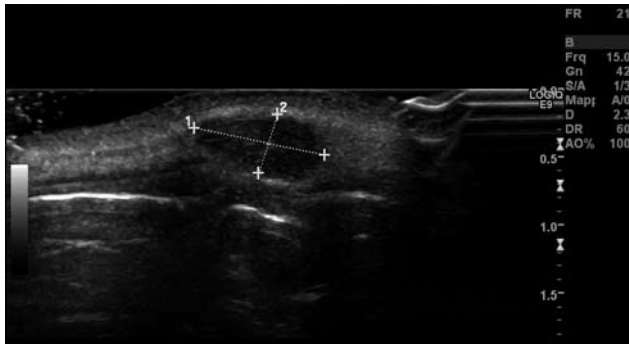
Ultrasound examination showed a homogeneous, hypoechoic-echo textured lesion, in the subcutaneous soft tissue with a small amount of posterior acoustic enhancement.
